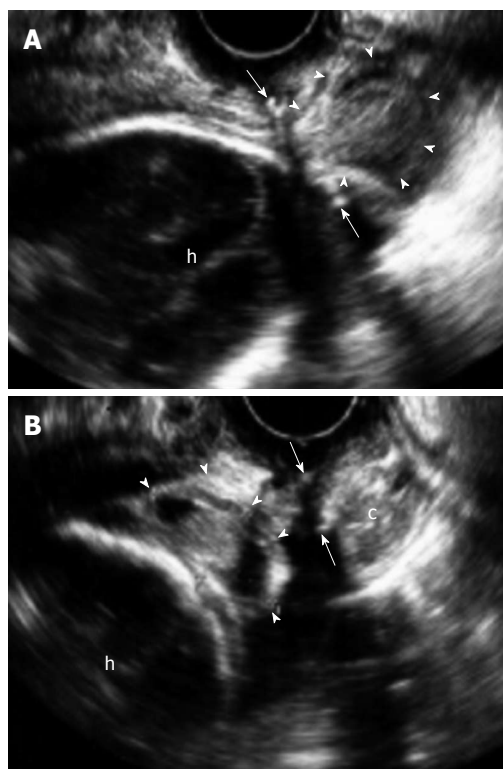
Transvaginal ultrasonography. A: A bulge (arrowheads) with an echogenic core was identified outside the cervical string (arrows); B: The bulge (arrowheads) was observed within the contour of the fetal head but inside the cervical string (arrows) 7 d after re-operation. h: Fetal head; c: Cervix.
